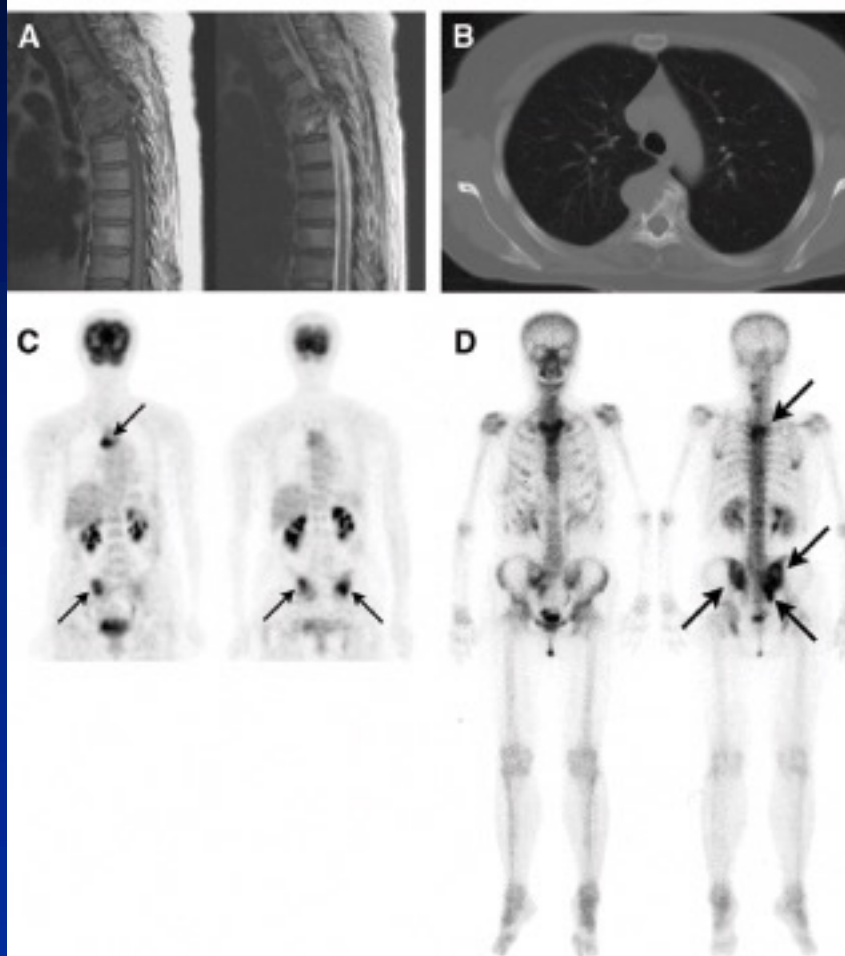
(A) T1-weighted MR image (left) shows massive lesion of low signal intensity, and T2-weighted MR image (right) shows lesion of high signal intensity. (B) CT scan shows osteolytic changes at thoracic spine (T4-T5). (C and D) ^{18}F -FDG PET coronal image (C) and $^{99\text{m}}\text{Tc}$ -bone whole-body scintigram (D) show high uptakes at thoracic spine (T4-T5), sacrum, and iliac bones (arrows).
